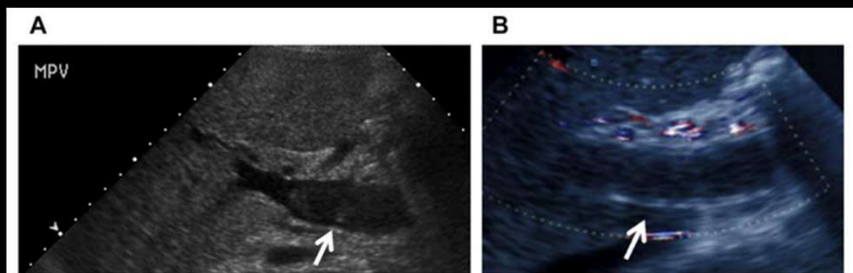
Visible thrombus (arrow) in the portal vein on a gray-scale image in the main portal vein. (B) It is more common for acute thrombus to be anechoic. In this patient, it is only visible as absence of flow on color Doppler (arrow). Flow is seen in the hepatic artery superficial to the portal vein.
